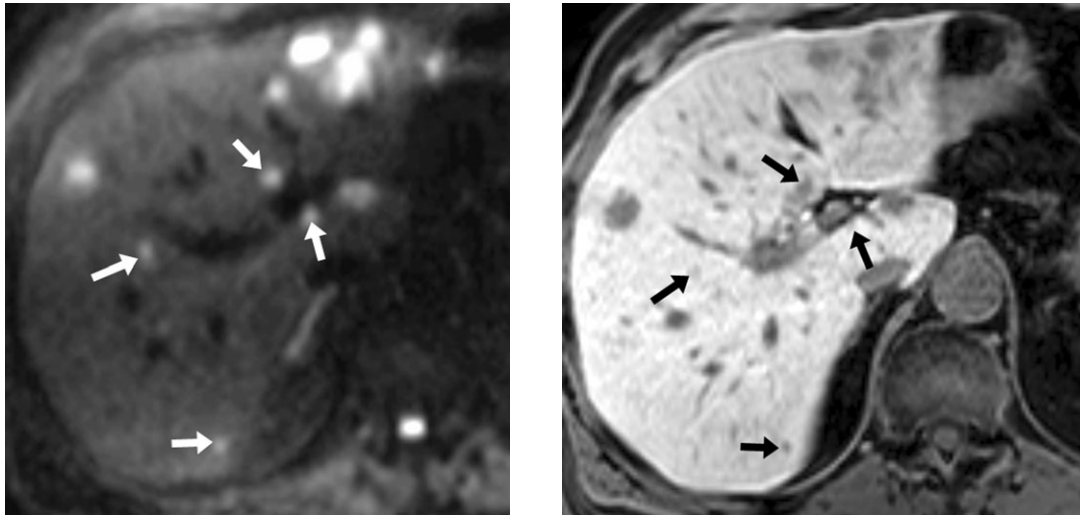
Diffusion-weighted MRI (DW-MRI) improves the detection of colorectal liver metastases. Left: delayed T1-weighted imaging after the administration of Gd-EOB-DTPA shows a number of hypointense metastases in the liver. Note, however, that the smaller metastases less than 1 cm in size (arrows) are easy to overlook, especially when they are located adjacent to intrahepatic vasculature, as they can mimic blood vessels. Right: DW-MRI performed using a b -value of 750 s/mm^2 reveals both the larger and smaller (arrows) metastases as conspicuous high signal intensity lesions.
